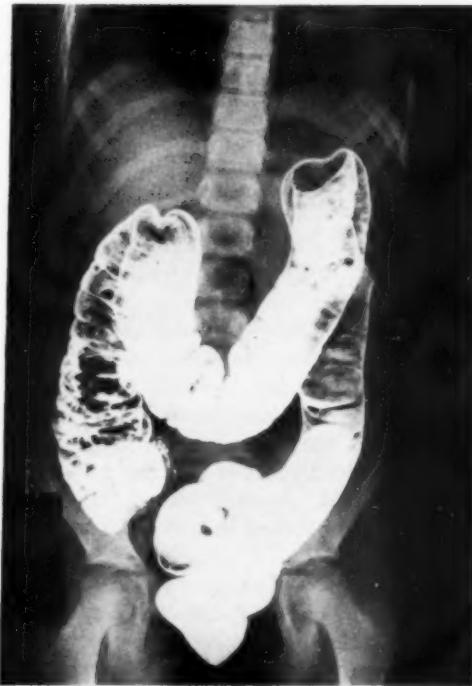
Roentgenogram of the colon of an 8-year-old girl, revealing numerous polyps.
